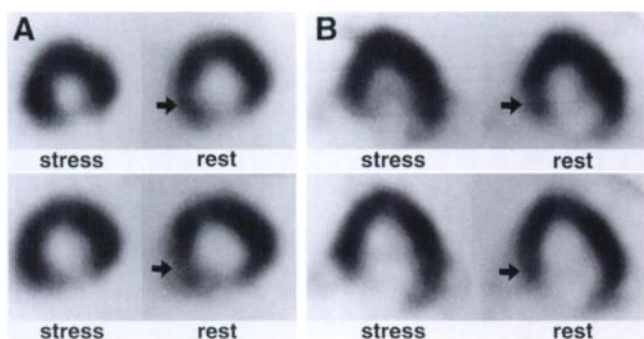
(A) Technetium-99m-MIBI myocardial SPECT (short-axis) shows decreased uptake in the inferior wall and normal uptake in the remainder of the LV wall on stress imaging and decreased uptake in the inferior and infero-septal walls (arrow) on rest imaging. (B) Technetium-99m-MIBI myocardial SPECT (horizontal long-axis) shows decreased uptake in the infero-septal wall (arrow) on imaging rest and normal uptake of the infero-septal wall during stress phase.
